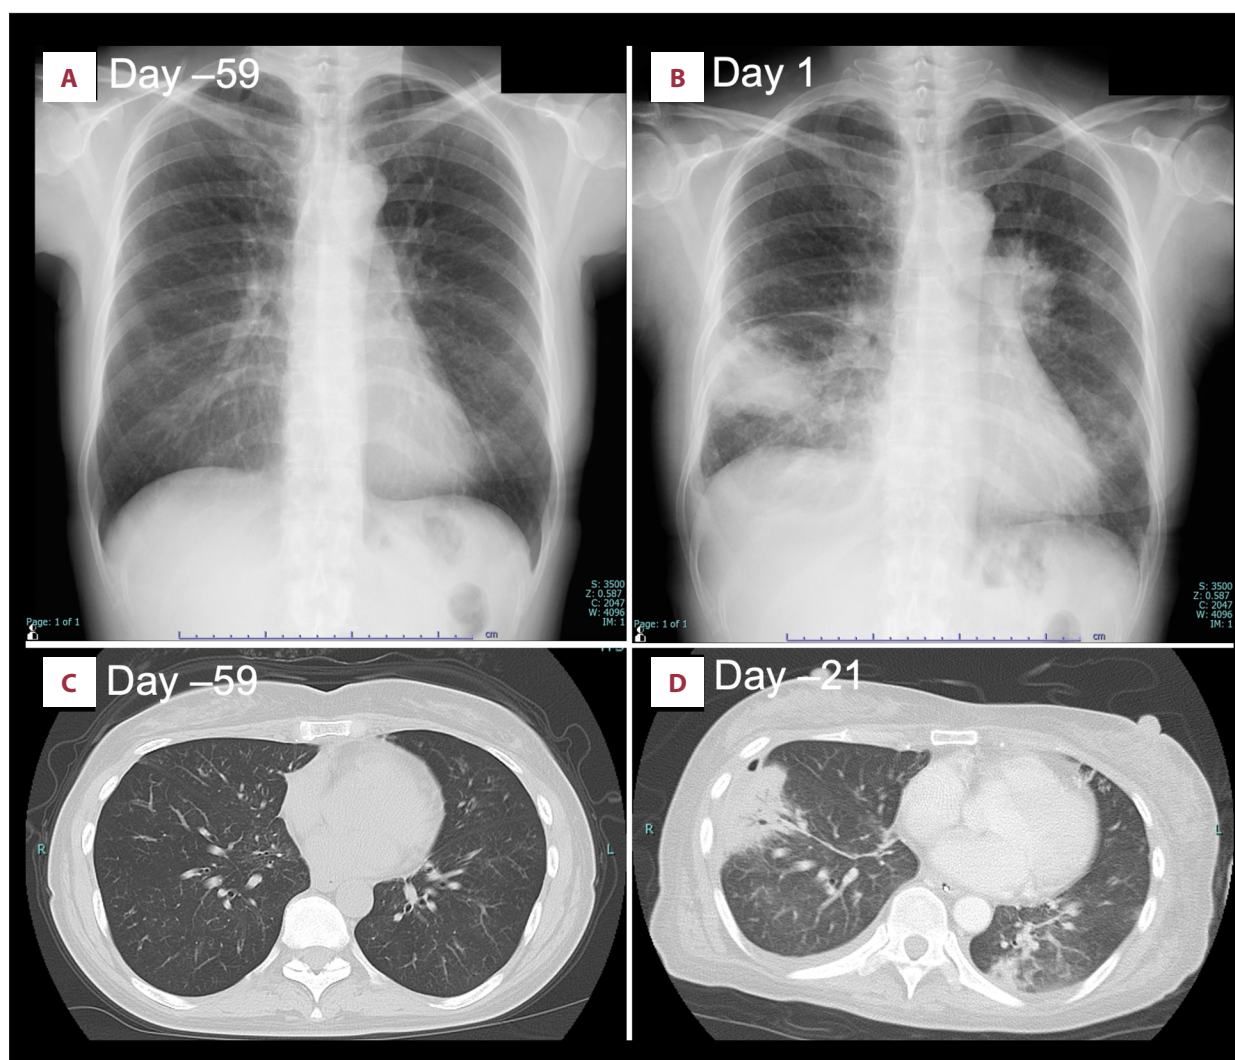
Chest imaging before admission and at admission. Chest radiography 59 days before admission showed no obvious pulmonary infiltrates (A), whereas chest radiography on hospital day 1 showed bilateral pulmonary opacities (B). Chest computed tomography 59 days before admission showed no corresponding lesions (C), whereas positron emission tomography-computed tomography 21 days before admission showed peripheral consolidation in the right lung and infiltrates in the left lower lobe (D).
